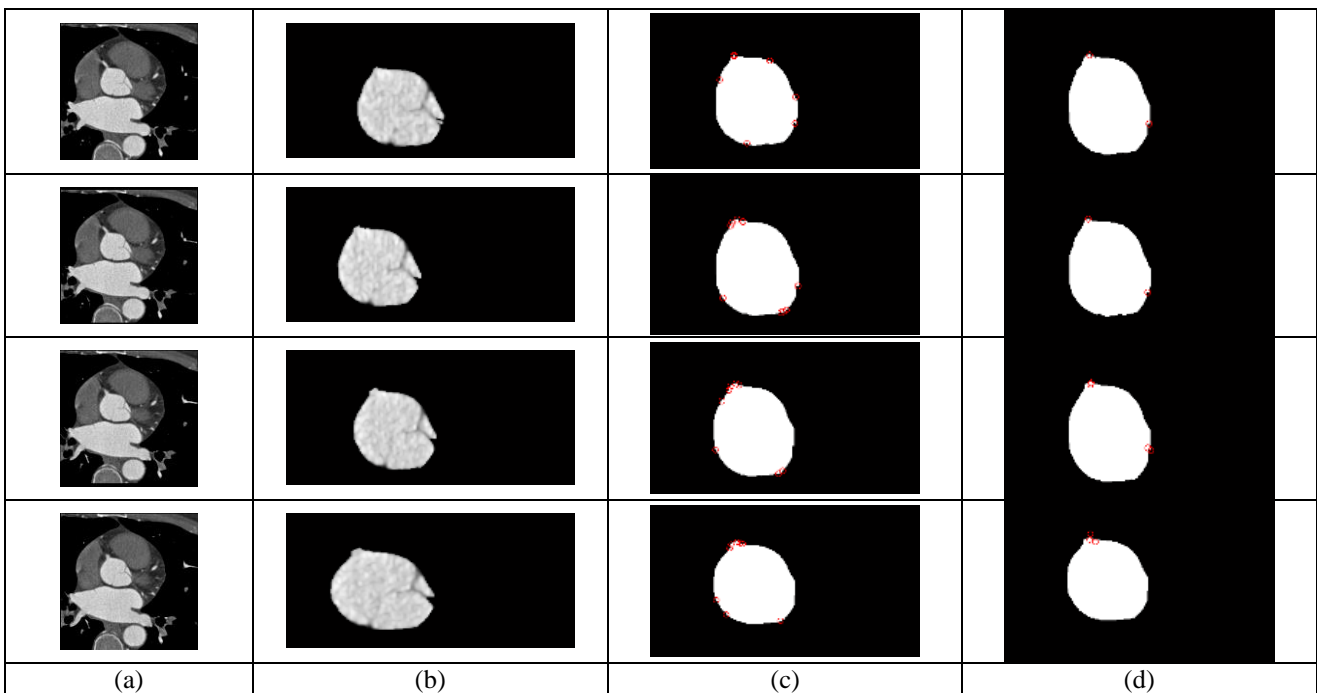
(a) Multiple sequential CTA slices revealing the aorta with left ostium emerging from the top left side of the aorta; (b) Segmented ascending aorta cross sections from the CTA slices; (c) Harris corner detection with $K=0.06$; (d) Harris corner detection with $K=0.2$.
